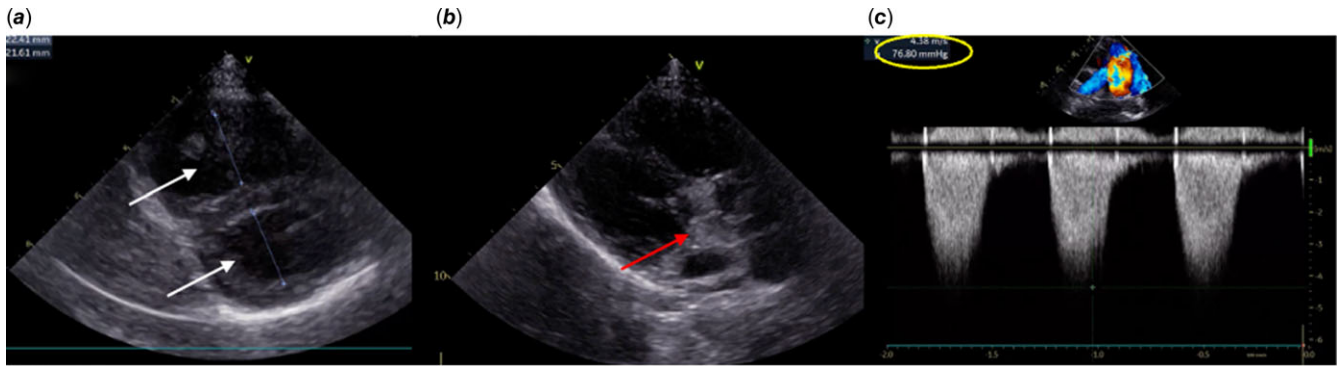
a: Parasternal short-axis papillary muscle view: dilated right chambers with a RV/ LV ratio = 0,9; b: Parasternal long-axis view: dysplastic, stenotic, bicuspid pulmonary valve; c: peak transpulmonary gradient of 76 mmHg.
